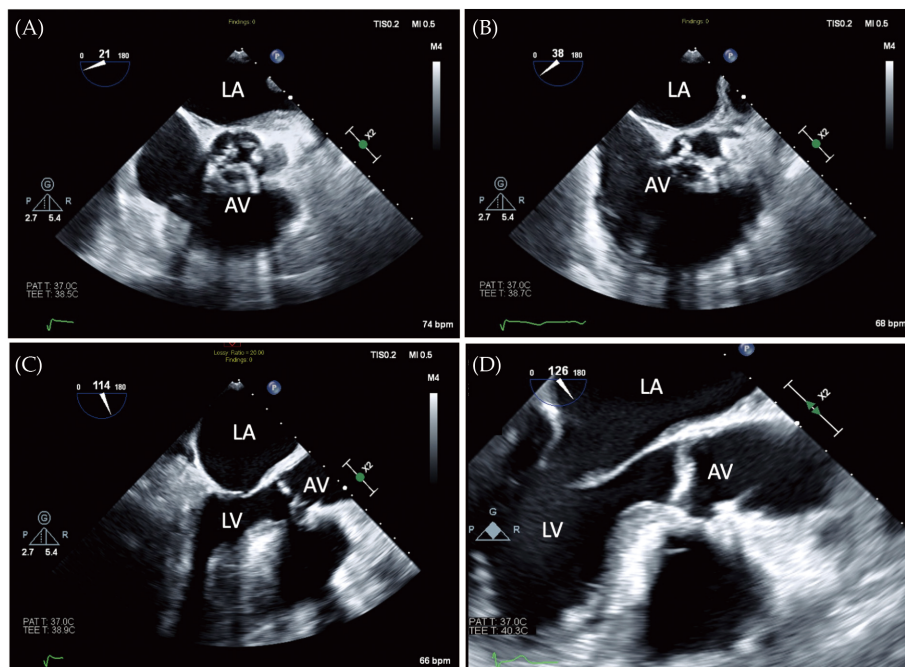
Transesophageal short axis (A, B) and long axis (C, D) systolic (A, C) and diastolic (B, D) frames demonstrating a heavily calcified aortic valve with acoustic shadowing. AV: aortic valve, LA: left ventricle, LV: left ventricle.
